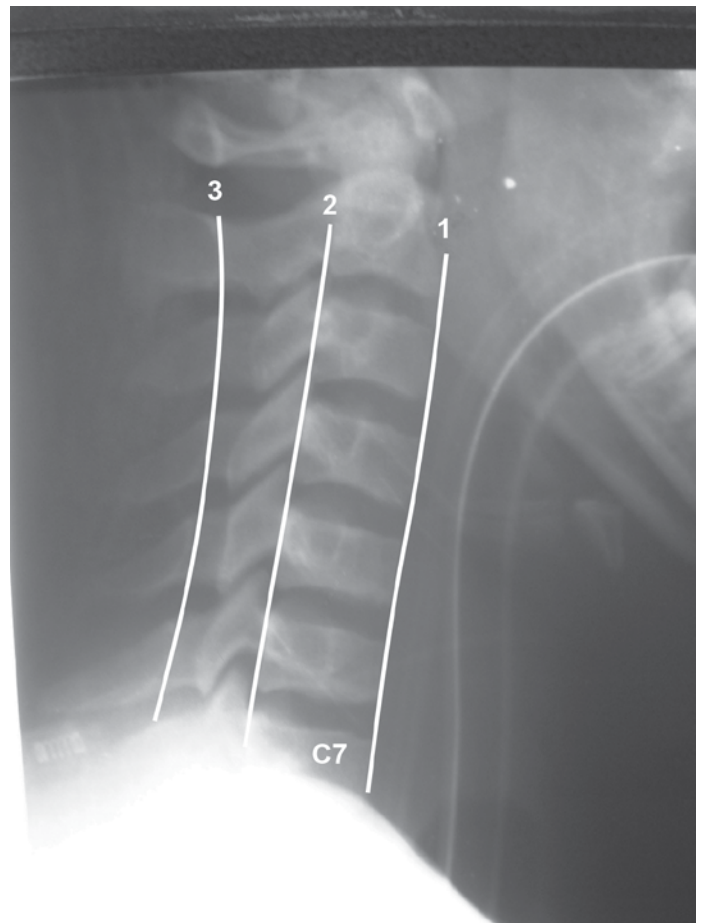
Normal lateral cervical spine X-ray showing the smooth lines (1) along the anterior margins of the vertebral bodies; (2) along the posterior margins of the vertebral bodies and (3) joining the bases of the spinous processes. Note that the body of C7 is not wholly seen and no part of T1 is seen and so this would not constitute an adequate lateral C-spine view
